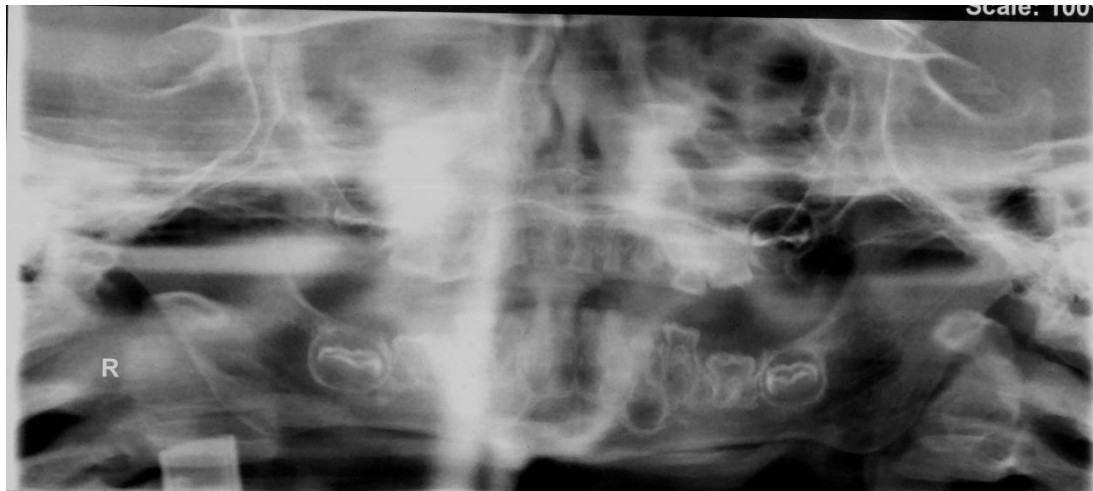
Panoramic radiograph of the 2.5-year-old child.
